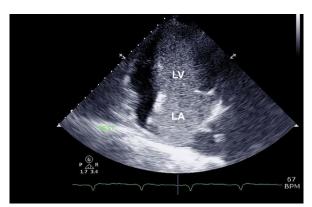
Transthoracic echocardiogram (apical 4-chamber view) shows saline contrast bubbles in the left atrium (LA) and left ventricle (LV).
